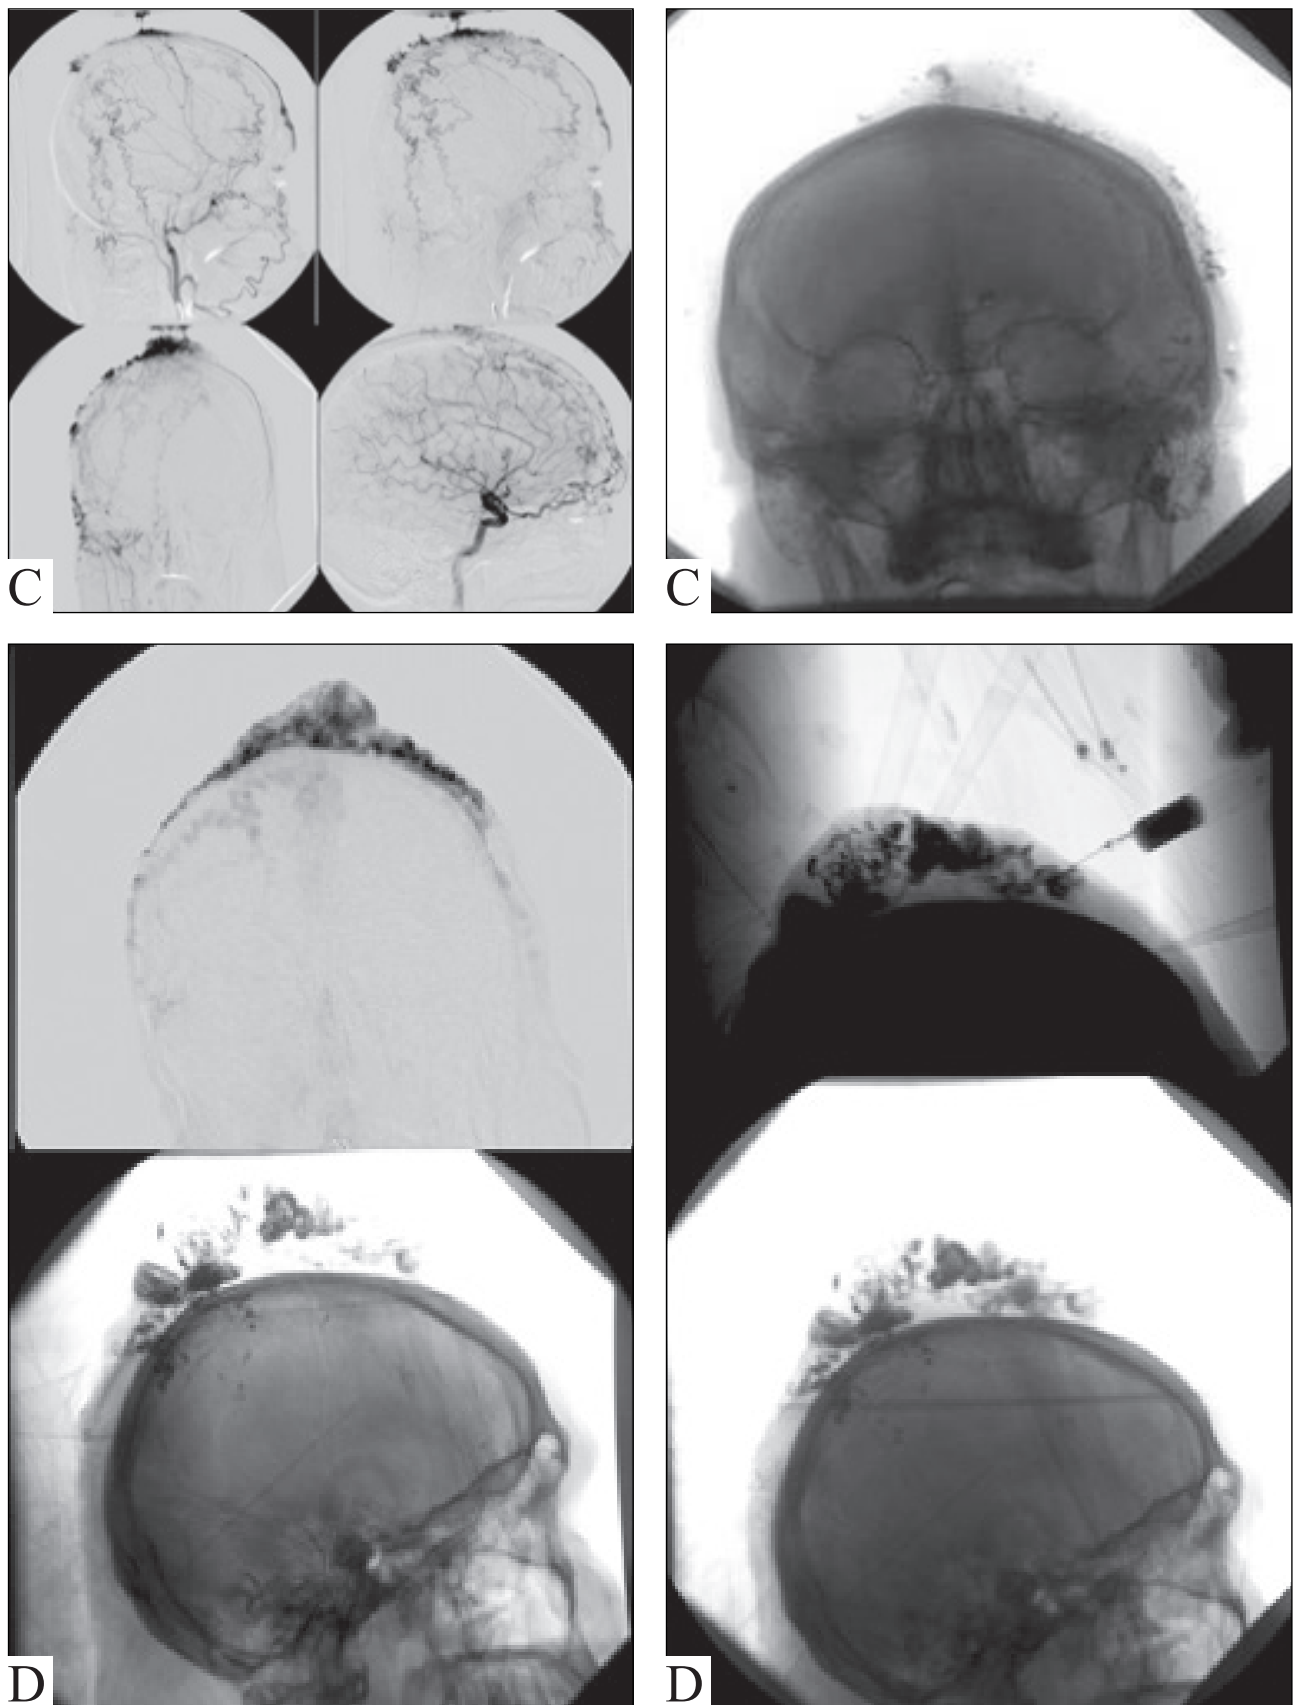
Male, 26 y.o. Hemangioma of frontoparietal area: *A* — Local changes before surgery: swelling, hyperemia, tumor bleeding. *B* — Patient's appearance after surgery. *C* — AG before surgery. Tumor's bilateral, mixed blood supply. *D* — Controlled embolization with additional percutaneous hystoacrylin jectin in tumor's stroma: digital subtraction before hystoacryl being inserted, introduction embolic agent. Bottom row — X-rays images in the lateral projection showing the distribution of embolic agent in the structure of the tumor
